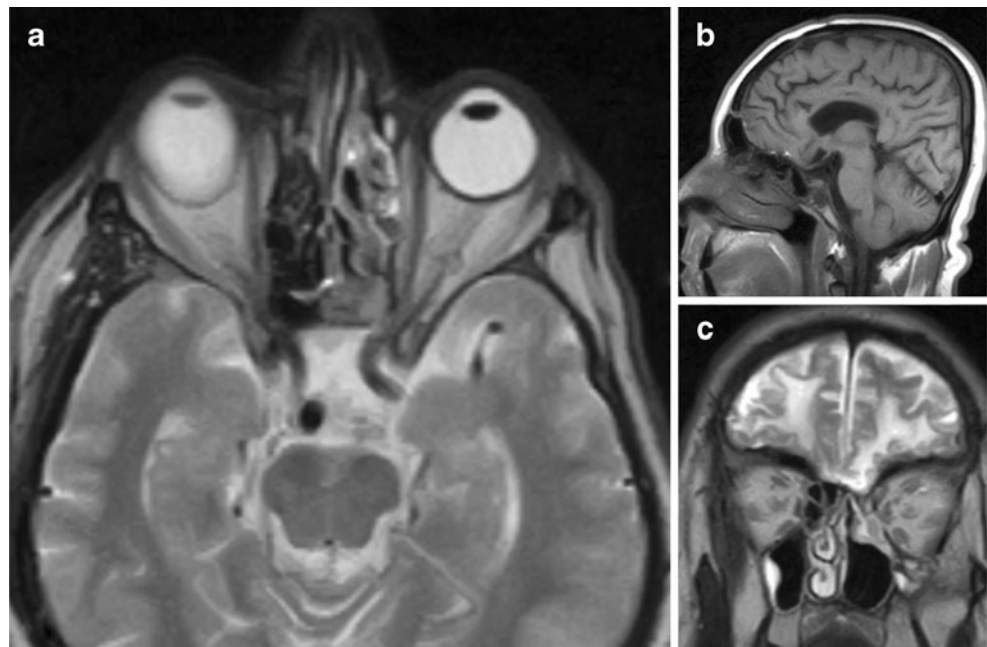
Follow-up brain MRI after 2 years of surgery, demonstrating no recurrence or residual tumor. a Axial T2, b sagittal T1, and c coronal T2-weighted images
